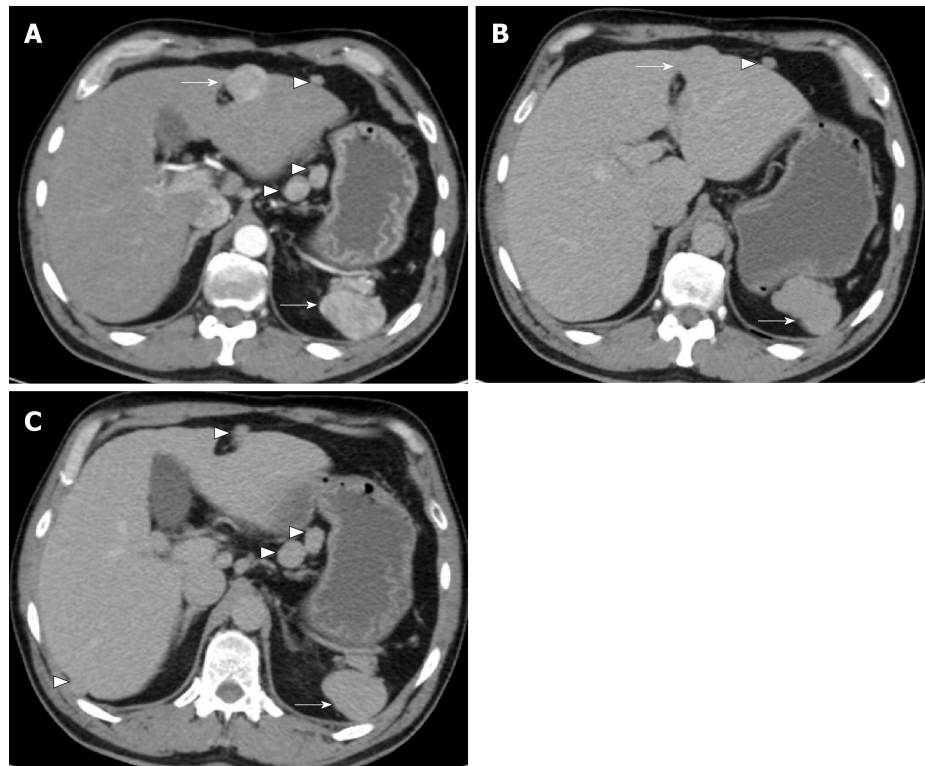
Computed tomography axial images from a patient with intrahepatic splenosis. A: arterial phase; a heterogeneously enhancing left lobe liver lesion is present 3 cm in diameter (thick arrow). Similar heterogeneously enhancing peritoneal and lesser sac nodules are seen (arrowhead). The deformed spleen shows typical heterogenous "zebra stripe" arterial enhancement; B and C: portal venous phase; the liver lesion (thick arrow) and the peritoneal and retroperitoneal nodules (arrowhead) are isodense and the same density as the spleen (thin arrow).
